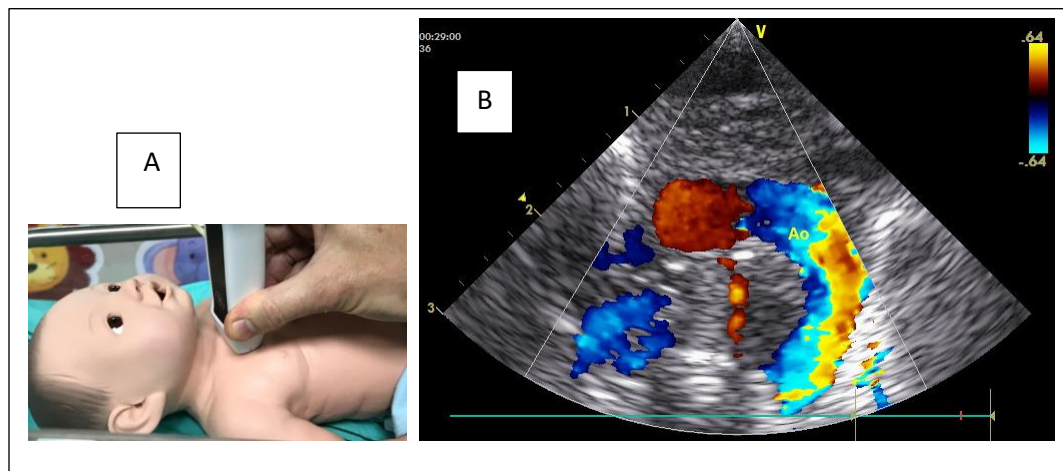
High parasternal window. A) Positioning of the transducer. B) Descending aorta.
